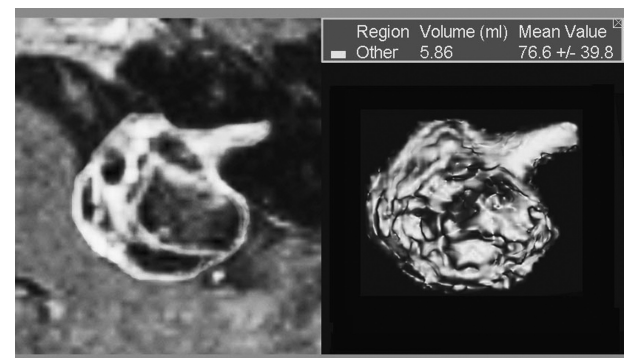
Example of volume measurement of left-sided vestibular schwannoma performed with the contour measurement method on a T1-weighted gadolinium enhanced MRI scan.
